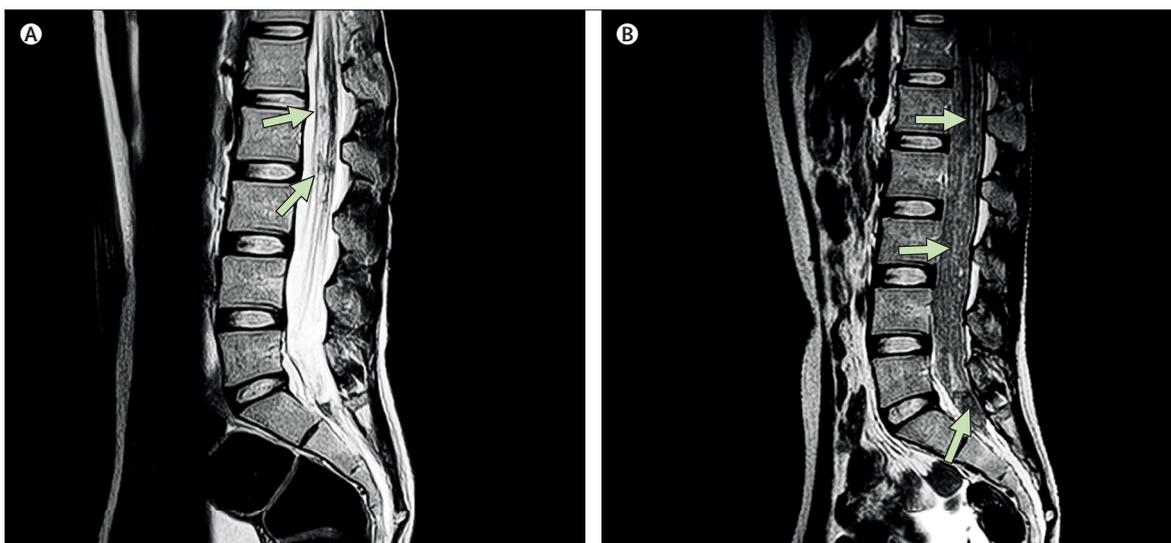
Lumbar MRI progression in a patient with meningeal melanocytosis
